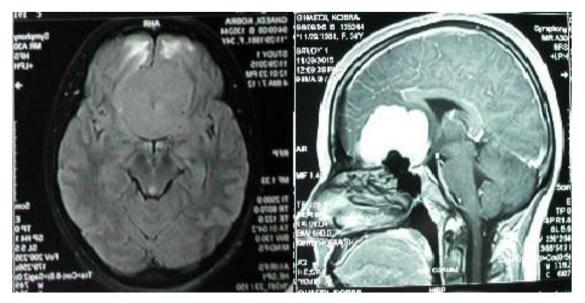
Tumor lesion in brain MRI Axial and Sagittal MRI show large extension of the mass lesion in supracellar region. Right side is axial FLAIR MRI and left side is T1-weighted post contrast MRI.
